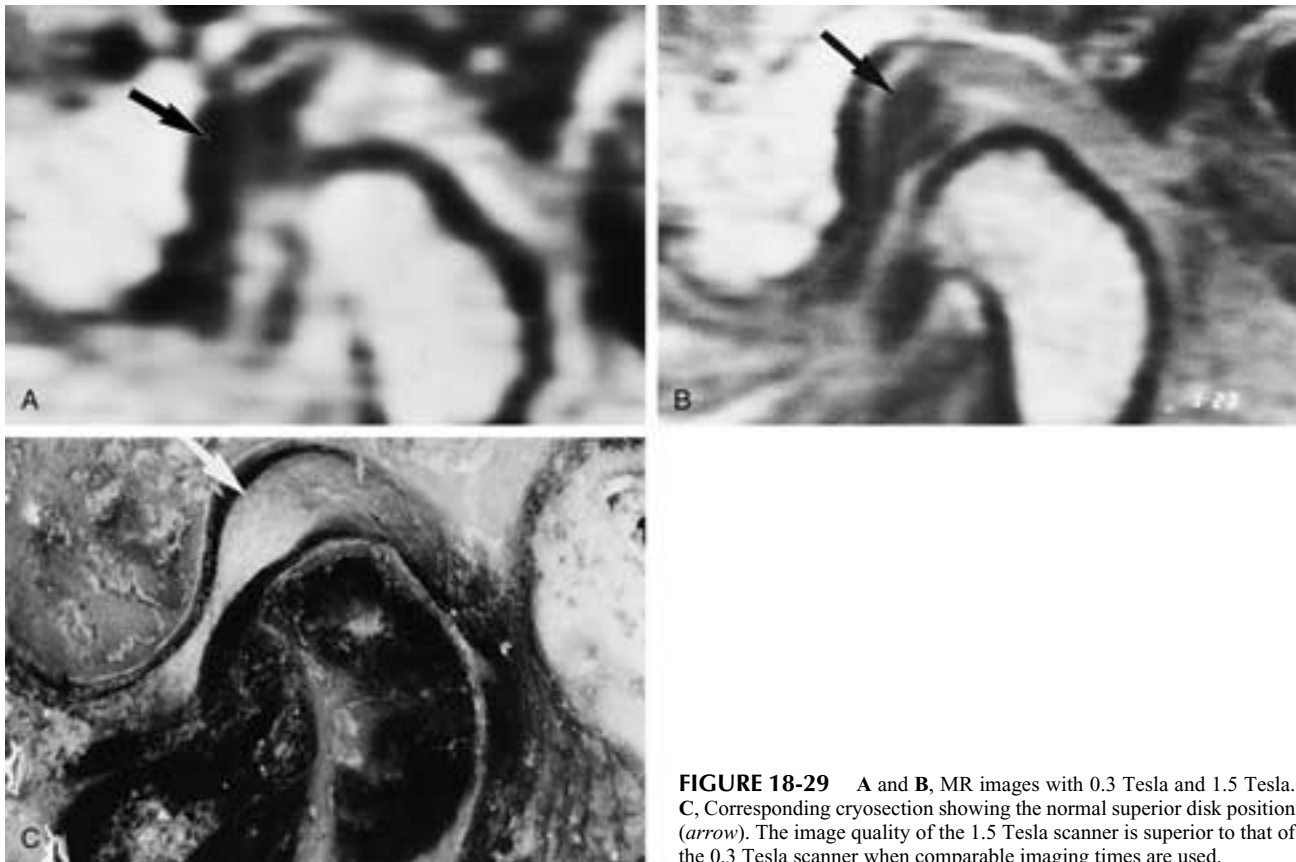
A and B, MR images with 0.3 Tesla and 1.5 Tesla. C, Corresponding cryosection showing the normal superior disk position (arrow). The image quality of the 1.5 Tesla scanner is superior to that of the 0.3 Tesla scanner when comparable imaging times are used.
